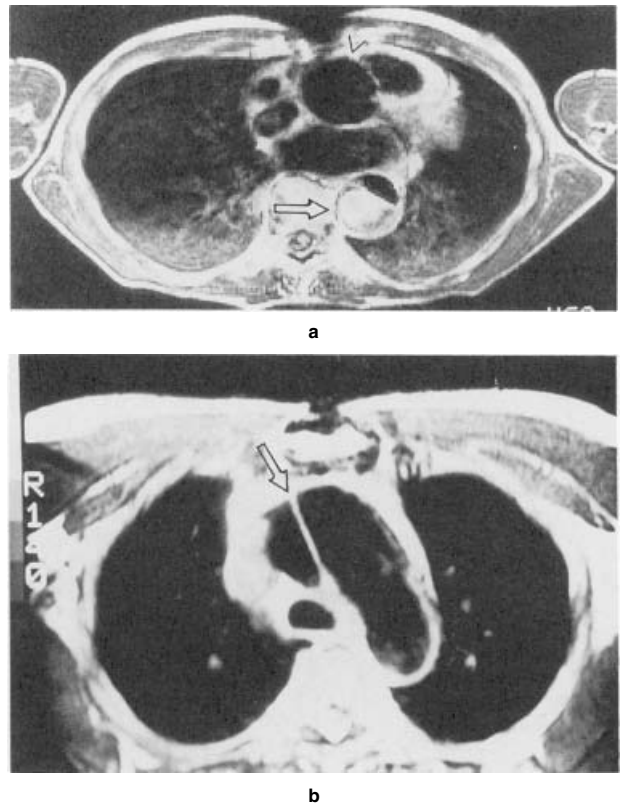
The Marfan aorta as revealed by magnetic resonance imaging. a: Axial image of the thorax through the level of the bifurcation of the main pulmonary artery. The aortic root is indicated by the arrowhead; it is moderately dilated. The arrow points to a dissected thoracic aorta that is minimally dilated. The scan is oriented with the dorsal surface down, and the patient's left to the right of the figure. b: Axial image of the thorax through the level of the aortic arch. The arrow points to the intimal flap of the dissected aorta. Orientation as in a.
